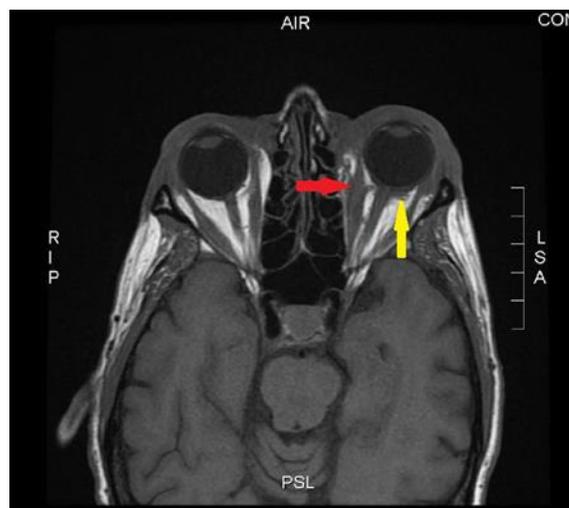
MRI showing significant medial rectus thickening (red arrow) compared to the other extraocular muscles. Also displayed is the tumor extension in the retrobulbar space, surrounding the optic nerve of the left eye (yellow arrow).
